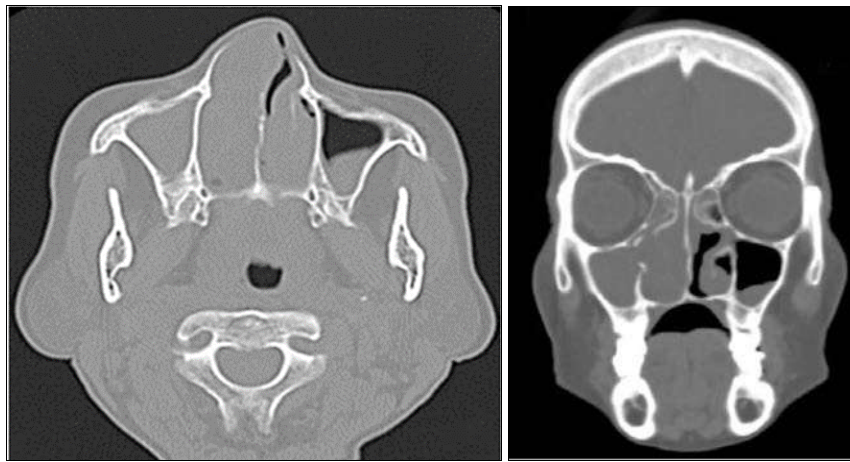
Coronal and CT scan image showing pansinusitis with right sided sinonasal polyposis
